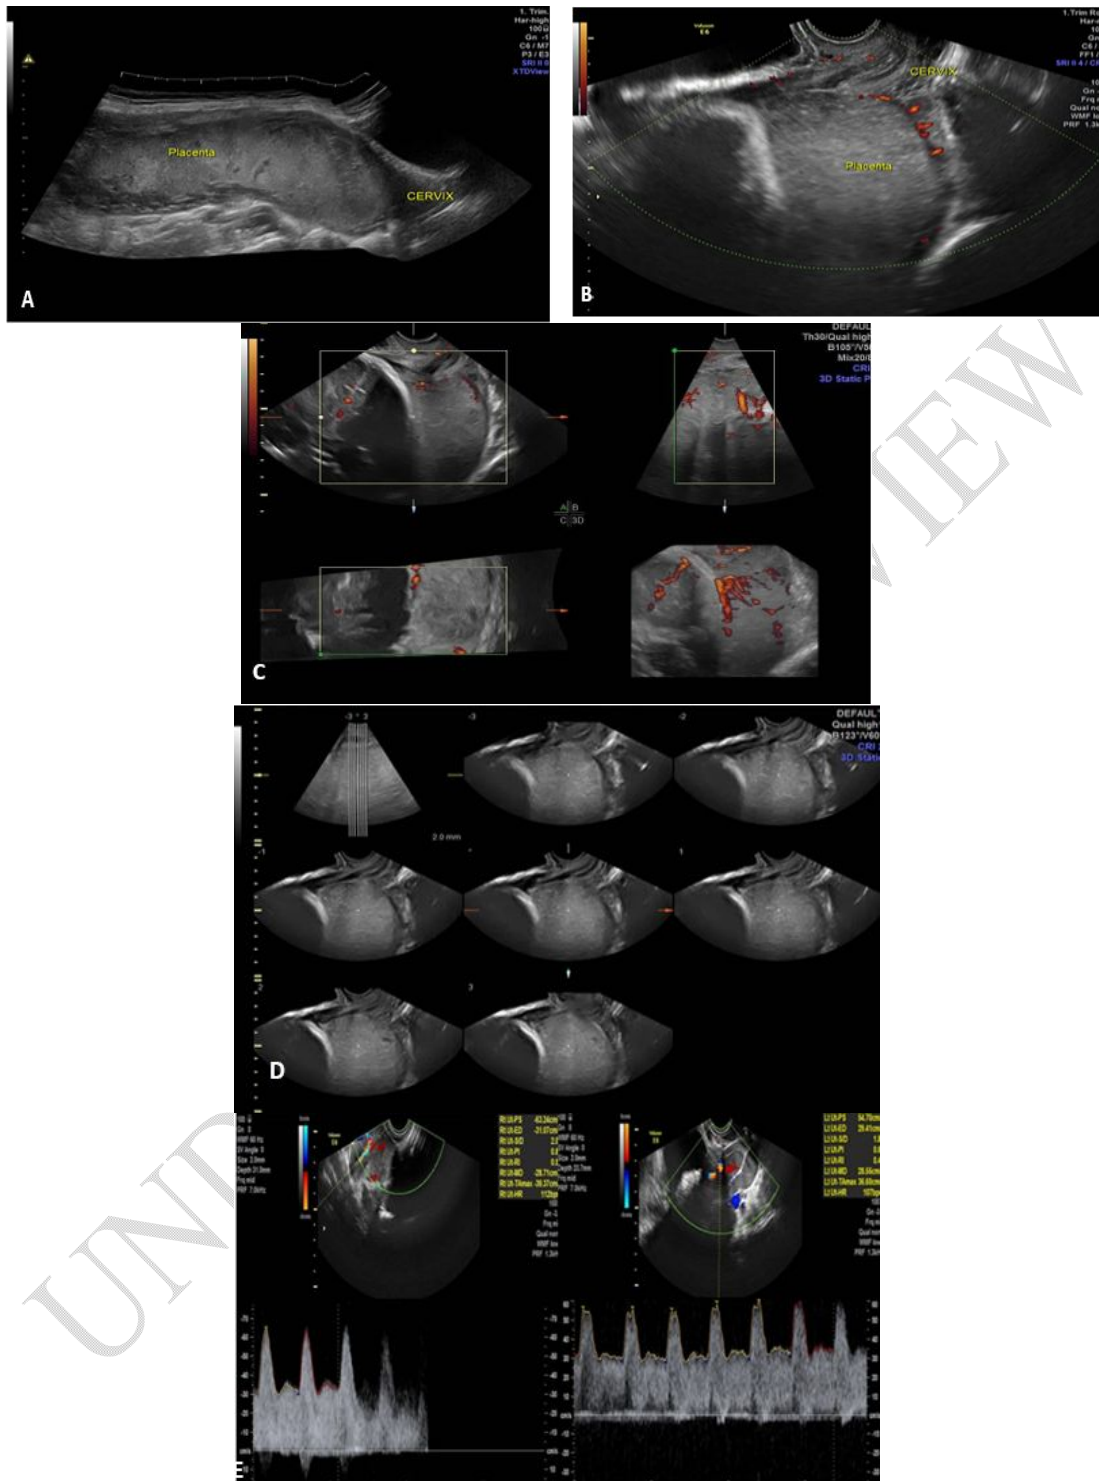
(A-E images): (A) 2D US panoramic view of placenta previa overlapping the internal cervical os with preserved Sonolucent retro placental area (placenta previa complete centralis). (B) Power Doppler image showing normal vessels between placenta and uterine wall with no evidence of placental lacunae. (C) 3DPD image showing no increased vascularity or placental lacunae. (D) 3D TUI cuts showing preserved retroplacental hypoechoic area, no placental lacunae confirming diagnosis of placenta previa complete centralis. (E) Uterine artery Doppler image showing measurements of PI & RI of right and left uterine arteries (0.82,0.51),(0.69,0.48) respectively.
